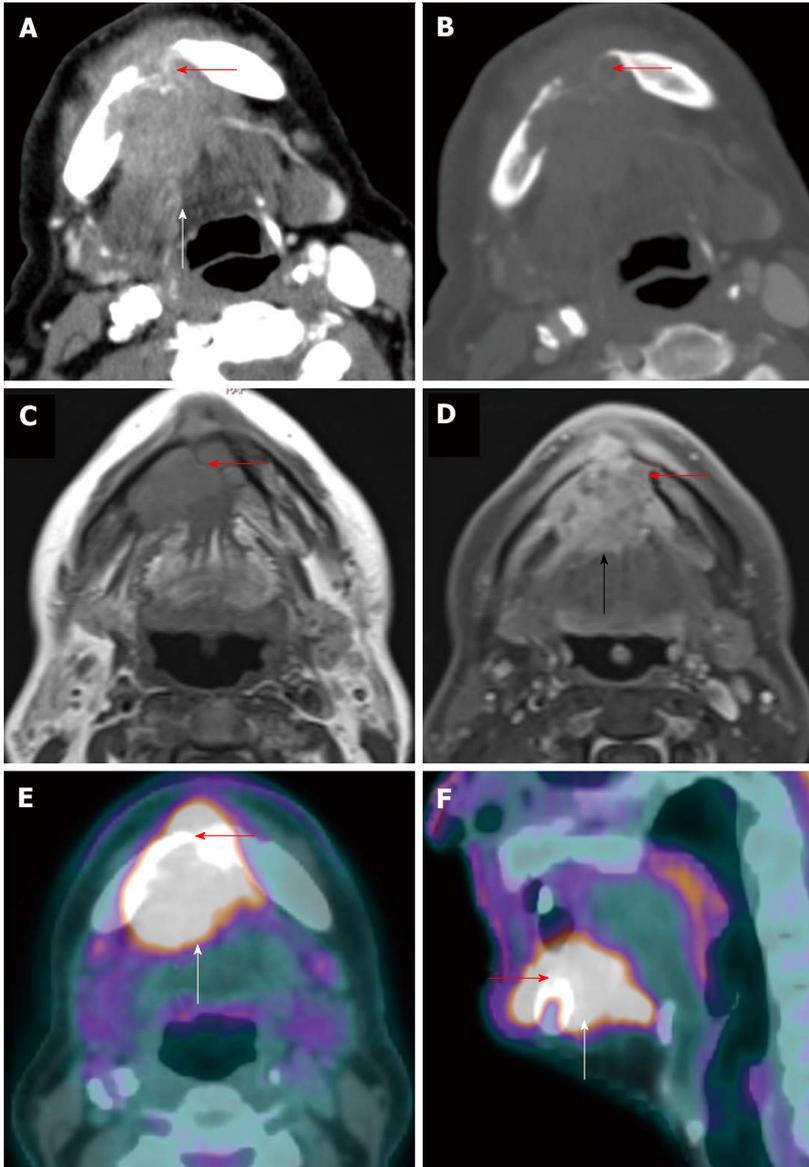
Positron emission tomography/computed tomography for detection of mandibular invasion. A T4a floor of mouth squamous cell carcinoma (white arrow) with through-and-through involvement (red arrow) of the anterior mandible is demonstrated on axial contrast-enhanced computed tomography (CT) (A: Soft tissue window; B: Bone window), axial contrast-enhanced magnetic resonance imaging (C: T1WI; D: Post contrast enhanced T1WI with fat saturation), and positron emission tomography/CT (E: Axial; F: Sagittal).
